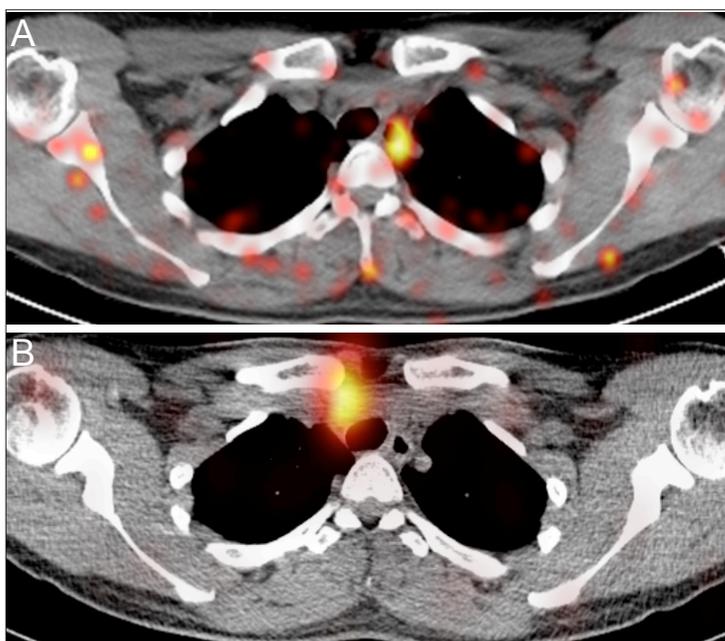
Patient (case no. 12) without pathological uptake of ^{124}I on PET/CT, only physiological uptake in the esophagus (A) and a positive ^{131}I SPECT/CT, showing uptake in retroclavicular lymph node, which was confirmed as metastasis after surgical removal (B).
